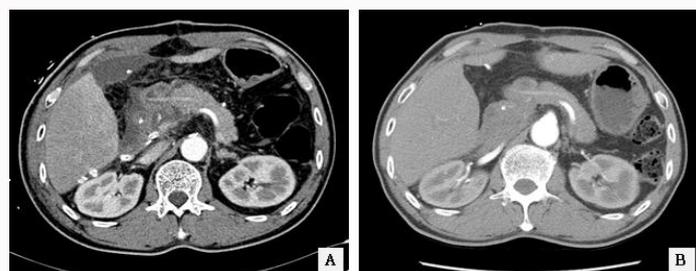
Typical Computed Tomography (CT) after invagination and binding pancreaticojejunostomy. Postoperative day 7 CT scan in the arterial phase (A) showed mild ischemia of the invaginated pancreas at proximal to the binding site, and the CT scan on postoperative 3 months (B) showed no demonstrable change of the invaginated pancreas.
